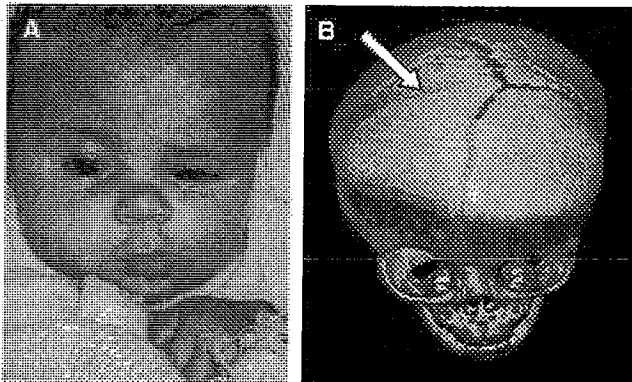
(A) Classic features of unilateral coronal synostosis. Note ipsilateral elevation of the brow and retrusion of the roof of the orbit, contralateral frontal bossing and diminution of the interpupillary fissure, ipsilateral twist of the nasal root, and contralateral point to the chin. (B) Arrow indicates the fused right coronal suture on reformatted CT imaging.
